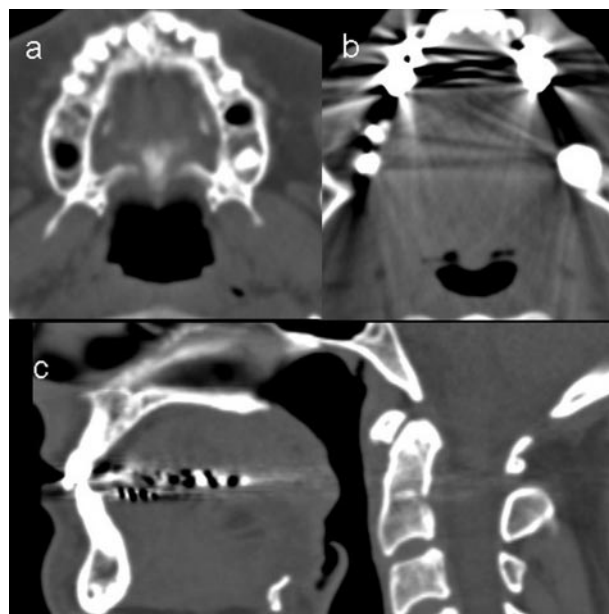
CT scans of a nonsnoring person. *Top left, a:* Area at the hard palate level ( $5.75 \text{ cm}^2$ ). *Top right, b:* Area at the most narrow level ( $1.73 \text{ cm}^2$ ). *Bottom, c:* Sagittal projection of the pharynx. The inspiratory pharyngeal narrowing ratio is 3.3.
